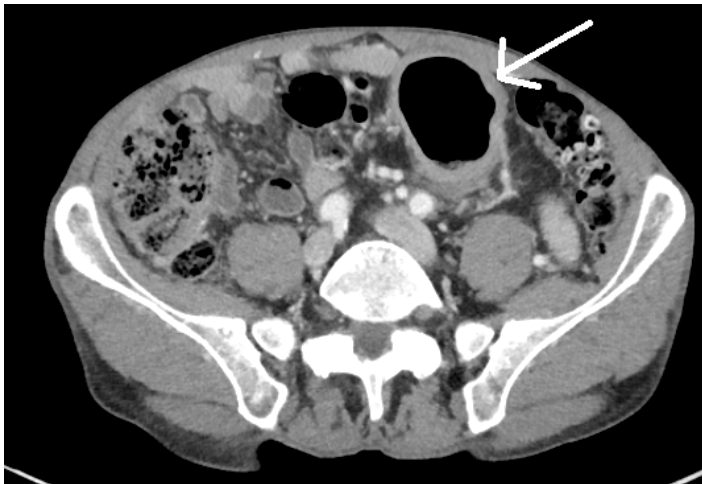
CT demonstrating a large diverticulum (arrow) with surrounding inflammation (axial view).
